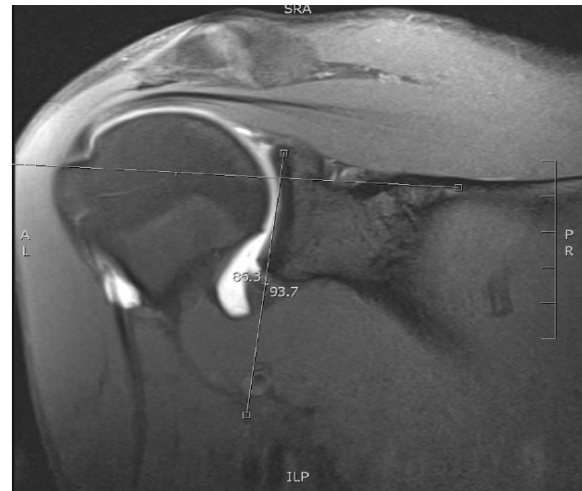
A coronal shoulder MRI image showing measurement of glenoid inclination (Hohmann & Tetsworth, 2015).
